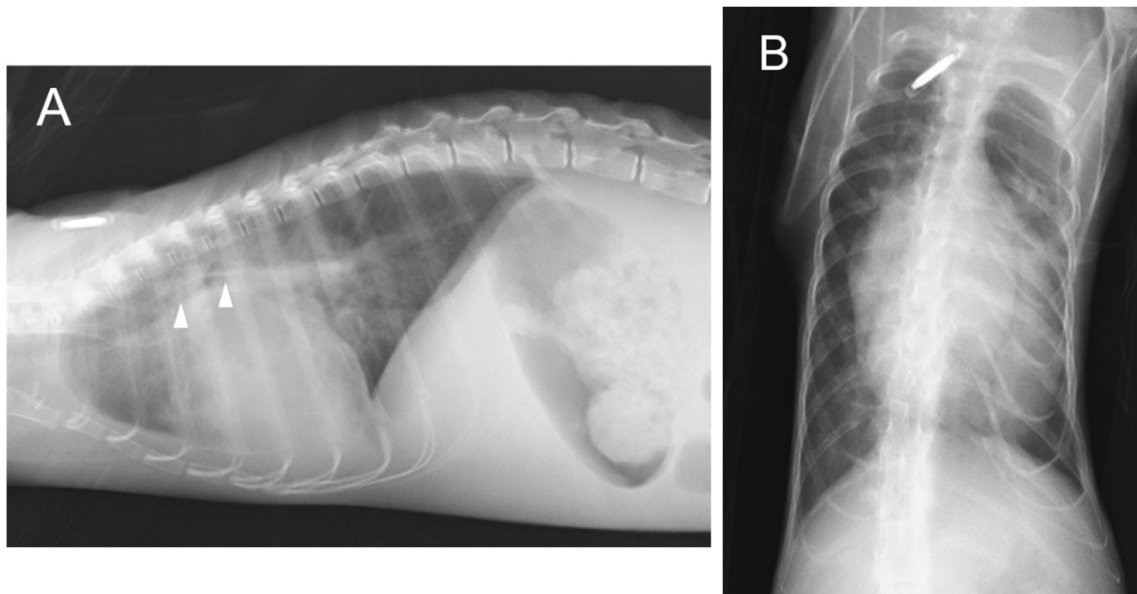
Thoracic radiographies: right lateral view (A) and dorsoventral view (B). Left-sided cardiomegaly is evident (vertebral heart score = 10.6 v, reference range = 8.5–9.3 v) resulting in dorsal displacement of the trachea and left mainstem bronchus (arrowheads). Prominent pulmonary vessels and a moderate perihilar interstitial pulmonary pattern are suggestive of cardiogenic pulmonary edema. Increased soft tissue opacity ventrally and mild retraction of the caudal lung lobe suggest the presence of a small volume of pleural effusion. Decreased abdominal serosal detail is consistent with a large volume of abdominal effusion.
